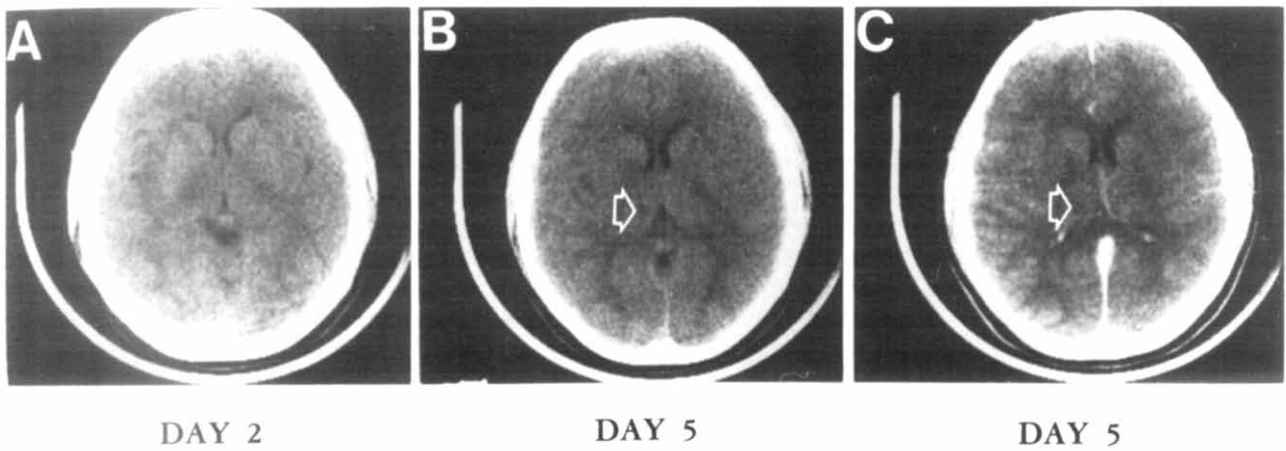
(A) Normal unenhanced cranial CT on the day after admission. Subsequent CTs (B) unenhanced and (C) enhanced demonstrate an area of infarction in the right middle cerebral artery distribution (arrow).
